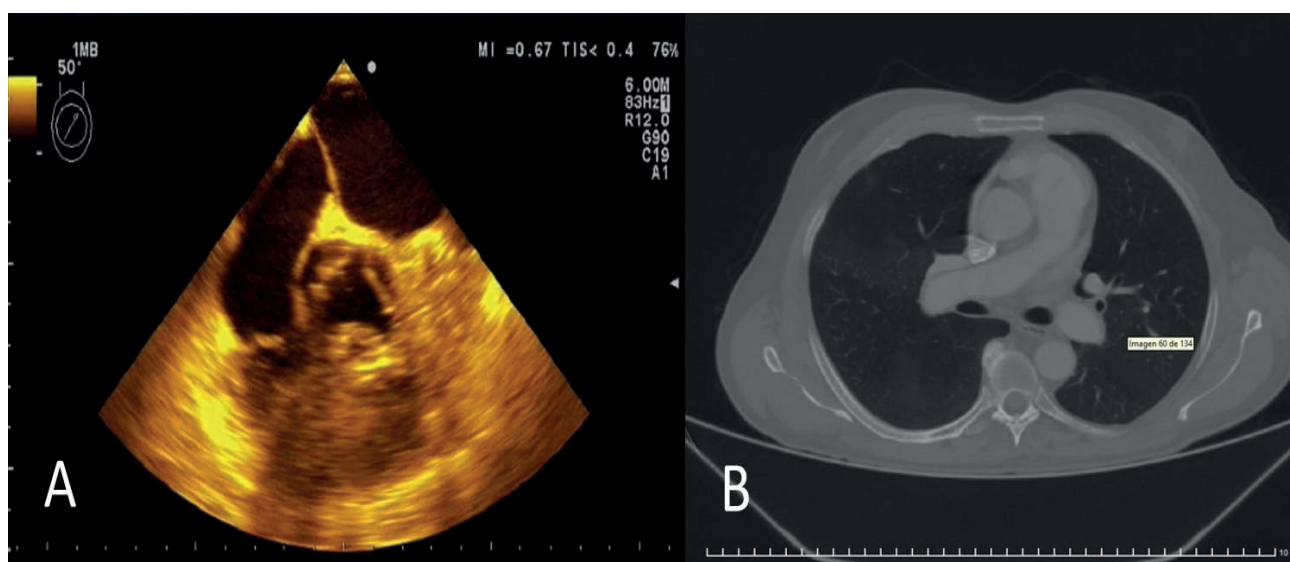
A. Transesophageal echocardiogram at 50° showing absence of thrombus in the right atrium and an intact interatrial septum. B. Contrast-enhanced chest CT scan showing no evidence of thrombus in the lumen of the right or left pulmonary arteries
